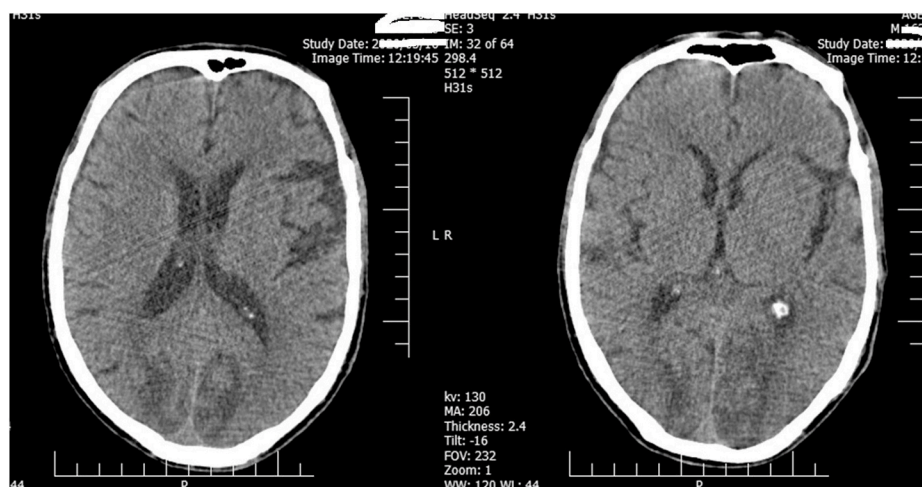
Brain CT scan revealed an acute bilateral occipital ischemia.
